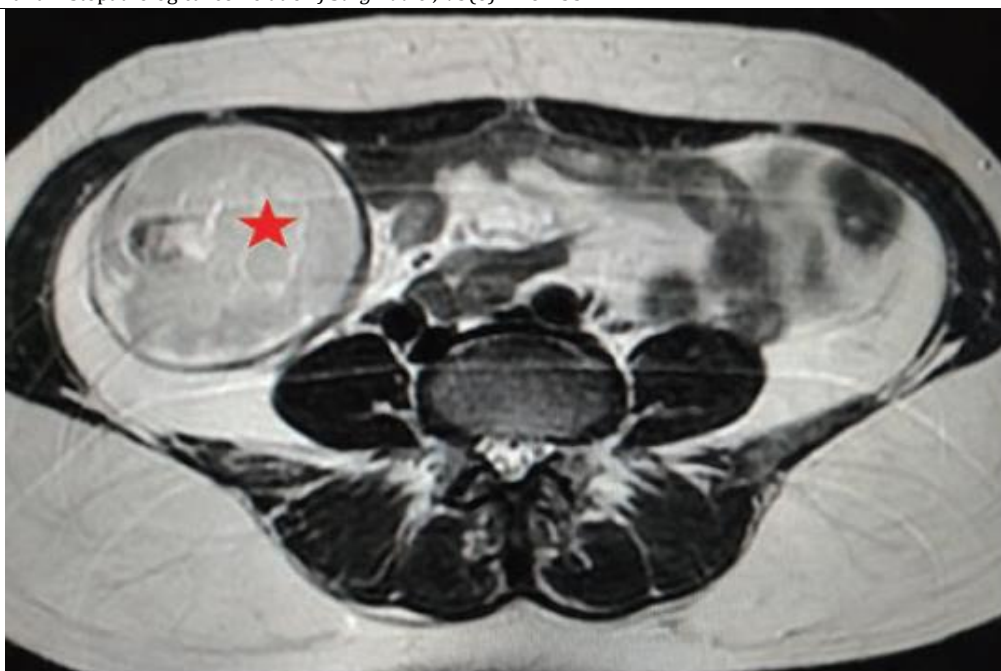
Axial T2-W MRI demonstrating a well-defined mixed signal intensity lesion (star) at right adnexa with few areas of fat fluid levels, foci low signal calcification and nodule in the wall of the right mass, S/O benign cystic teratoma. MRI, magnetic resonance imaging.
